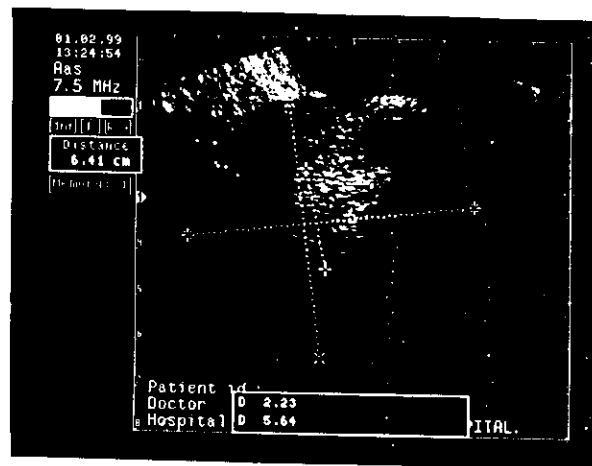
Shows sonographic picture of endometrial hyperplasia.
